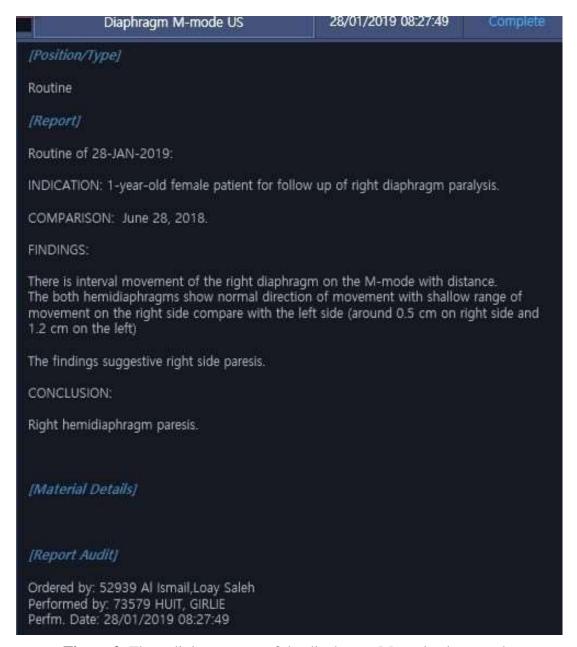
The radiology report of the diaphragm M-mode ultrasound
